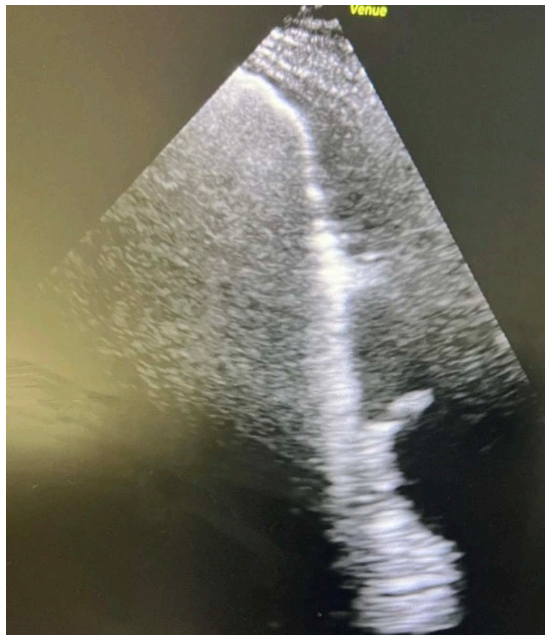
Cardiac ultrasound.
